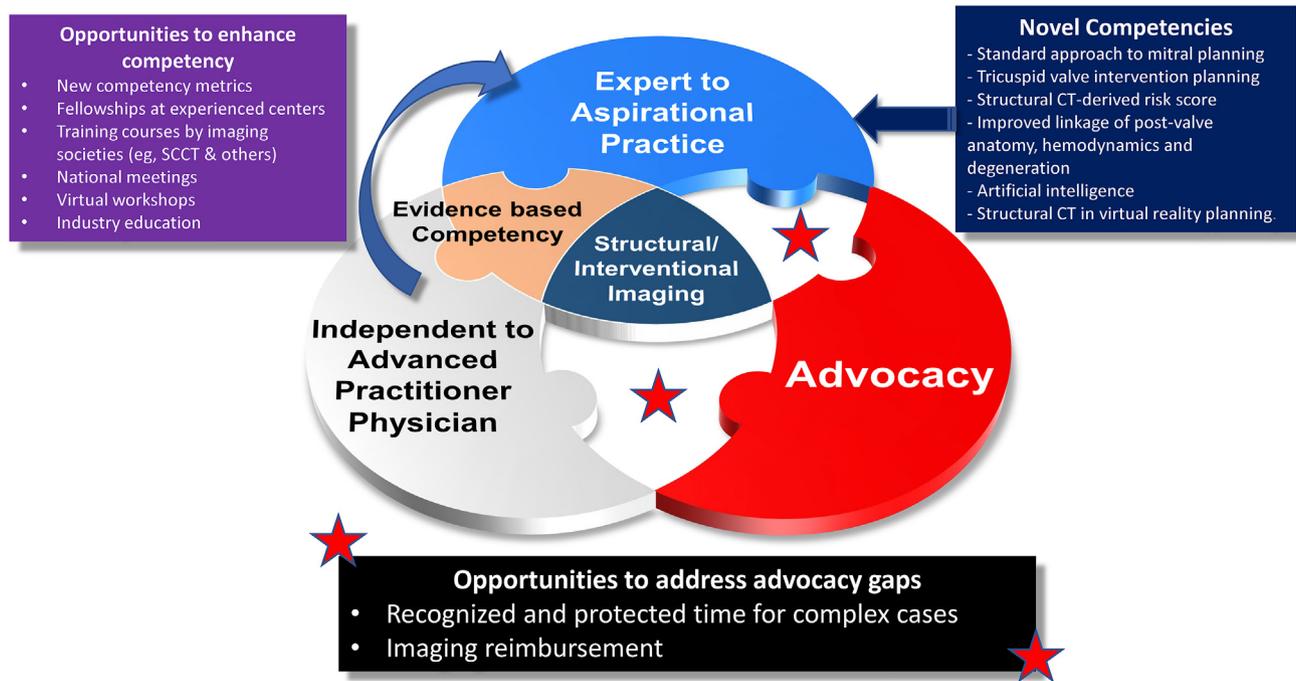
Evidence Based Competency and Advocacy in Structural Imaging. The steps to cardiovascular computed tomography structural imaging excellence start with foundational education and training for exposure and achievement of baseline competency skills in the early years of formal training; next to acquire independent and advanced competency skills by progressing from classic, uncomplicated cases to ever increasing complex and niche applications during the final years of formal general and subsequent subspecialty/advanced fellowship. Then, beyond fellowship, lifelong learning to achieve expertise through real-world clinical case experience, continuing medical education and training into novel and aspirational frontiers. These competency efforts should be supported by ongoing and renewed advocacy efforts to support the next generation of structural imaging physicians to acknowledge this expertise through protected time and appropriate reimbursement for structural imaging physician centrality in the multi-disciplinary heart team.
